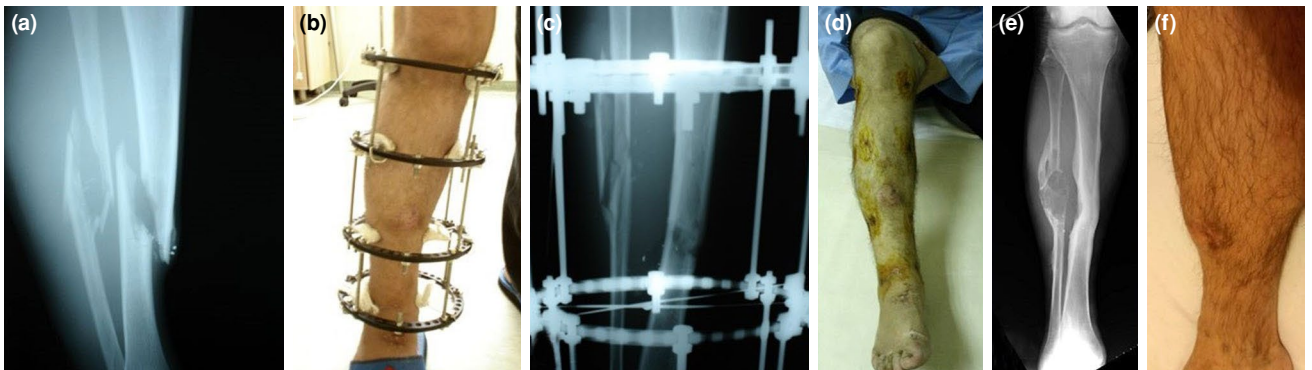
A-19-year follow-up of a 21-year-old troop injured by gunshot. (a) An anteroposterior radiograph of tibia fracture. (b) view of weight bearing extremity after Ilizarov surgery. (c) An anteroposterior radiograph of fractured tibia and fibula after surgery. (d) View of extremity after removal of frame. (e) An anteroposterior radiograph of tibia at 19 years of follow-up. (f) View of extremity at 19 years of follow-up.
